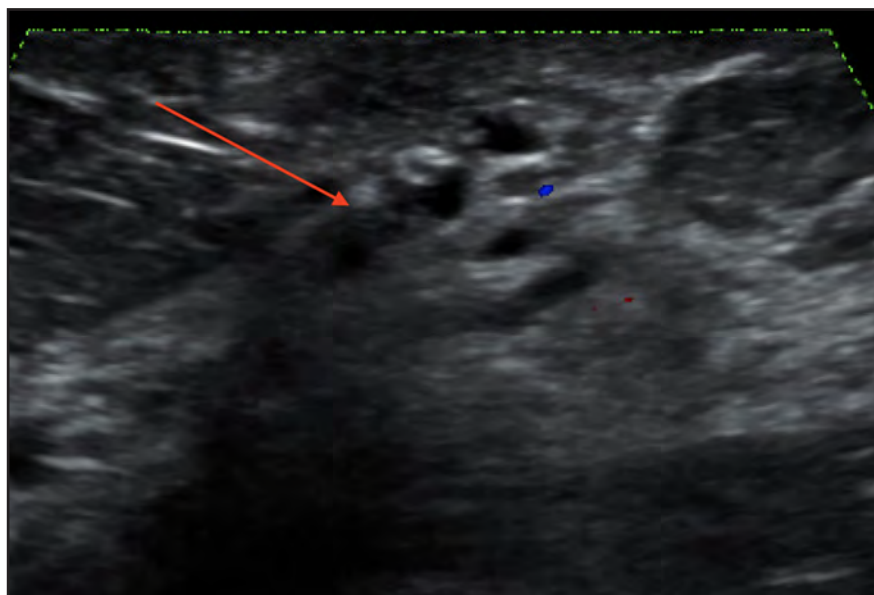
Target ultrasound of the left retroareolar region at the level of the nipple demonstrates an intraductal mass (arrow). Images obtained with color flow, which does not demonstrate internal vascularity. The sonographic findings were thought to represent debris.
